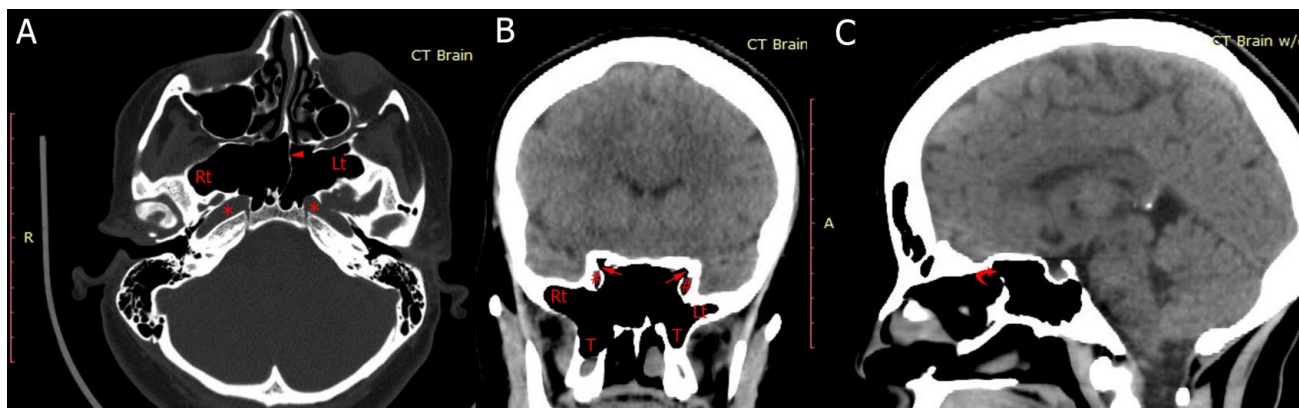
Sample of CT scan cuts demonstrating the extension of sphenoid sinus pneumatization in A: Axial, B: Coronal, and C: Sagittal planes. Rt: right, Lt: left, \*: carotid canal, arrowhead: sphenoid septum, #: optic canal, arrow: pneumatized lesser wing, T: pneumatized pterygoid process, curved arrow: partially absent spheno-ethmoidal septum.
